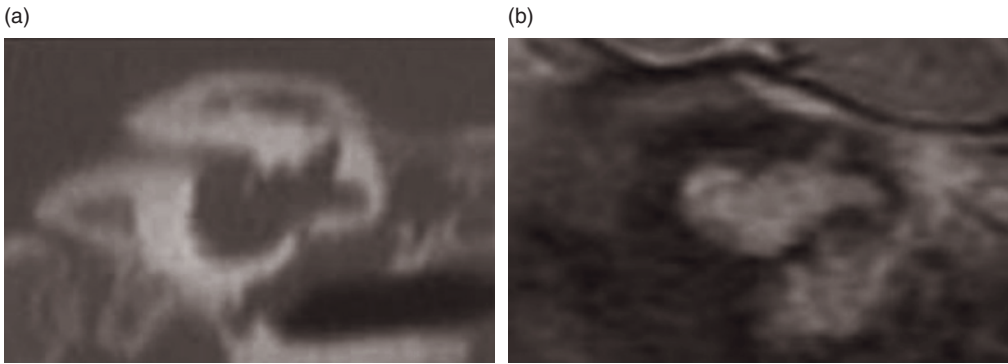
'Incomplete partition type I': coronal CT (a) and T2-weighted MR (b) images.
